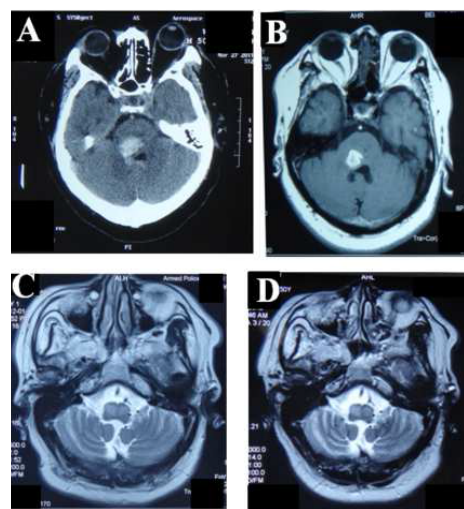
A Brain CT scan showing dorsal pontine hemorrhage on Mar 27th, 2011 (Figure A). MRI revealed high intensity lesions in dorsal pons on sagittal T1 on Apr 22nd, 2011 (Figure B). MRI sagittal T2 revealed high intensity lesions indicating hypertrophic olivary degeneration on Dec 1st, 2011 (Figure C). Brain MRI T2 revealed a symmetric enlargement of the inferior olivary nuclei with high signal intensity on Feb 28th, 2012 (Figure D).
